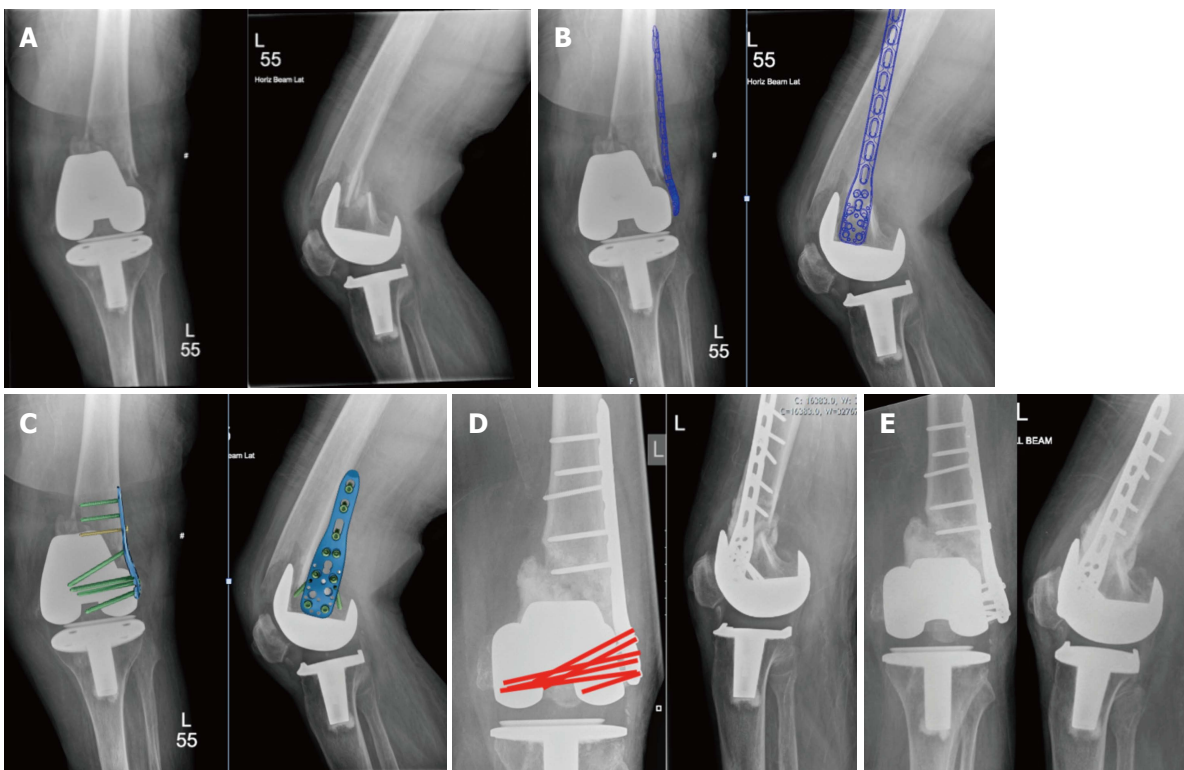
Radiograph series of patient B. A: Anteroposterior and lateral injury radiographs; B: Templated anteroposterior radiograph showing proposed position of implant; C: Anteroposterior and lateral radiographs with PHILOS plate image superimposed to show orientation of screws; D: Post-operative radiographs at 5 mo with orientation of screws behind the femoral component shown in red; E: Anteroposterior and lateral radiographs at 16 mo post-op.
